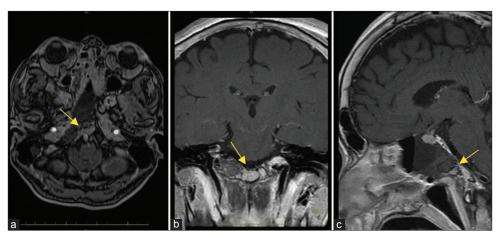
(a) In the spoiled gradient recalled acquisition in the steady state-gradient refocused axial image and (b and c) T1-weighted magnetic resonance imaging using gadolinium-based contrast coronal and sagittal images, the residual tumor (arrows) can be seen in the central area of the clivus covered with the cortical bone.
